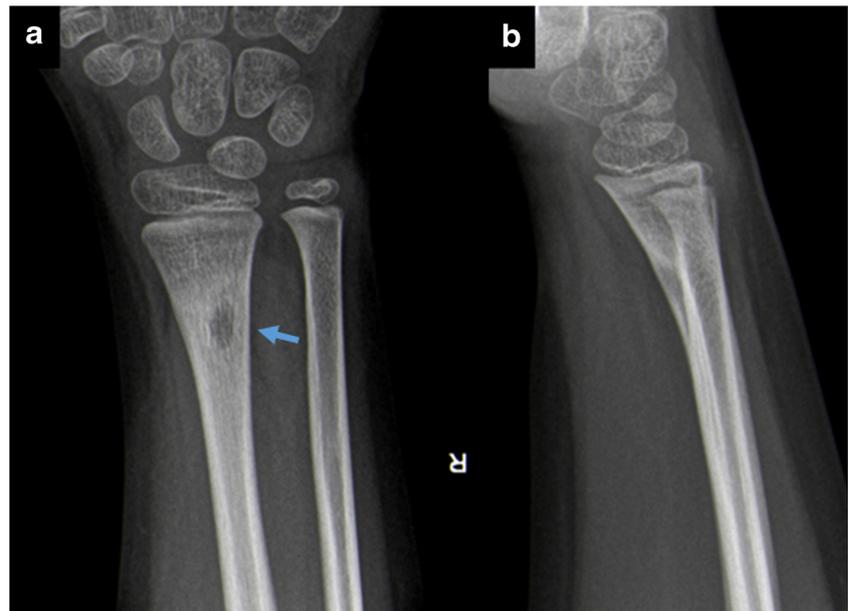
Radiographs of the right wrist, 10 weeks following injury. a Postero-anterior and b lateral views where a new lucent lesion within the ventral cortex of the radius is identified (*arrow*)
